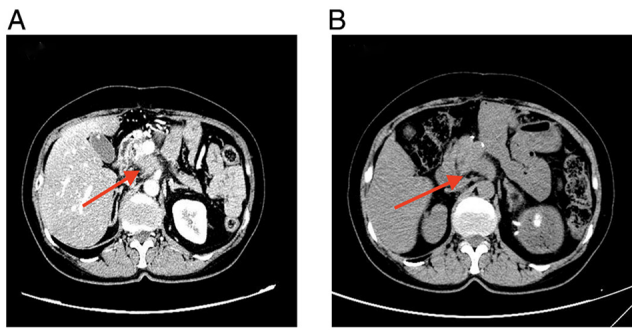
Imaging findings of suspected postoperative recurrence and radiological response to targeted therapy. (A) Contrast-enhanced CT performed in September 2024 revealed an oval soft-tissue lesion located in the portal vein-superior mesenteric artery space, with a maximal diameter of ~1.90 cm and prominent enhancement, suggesting clinically suspected locoregional recurrence. (B) Follow-up CT performed in December 2024 demonstrated a reduction in the size of the lesion at the same site, with the maximal diameter reduced to ~1.63 cm, suggesting radiological regression of the suspected recurrent lesion after targeted therapy. CT, computed tomography.
